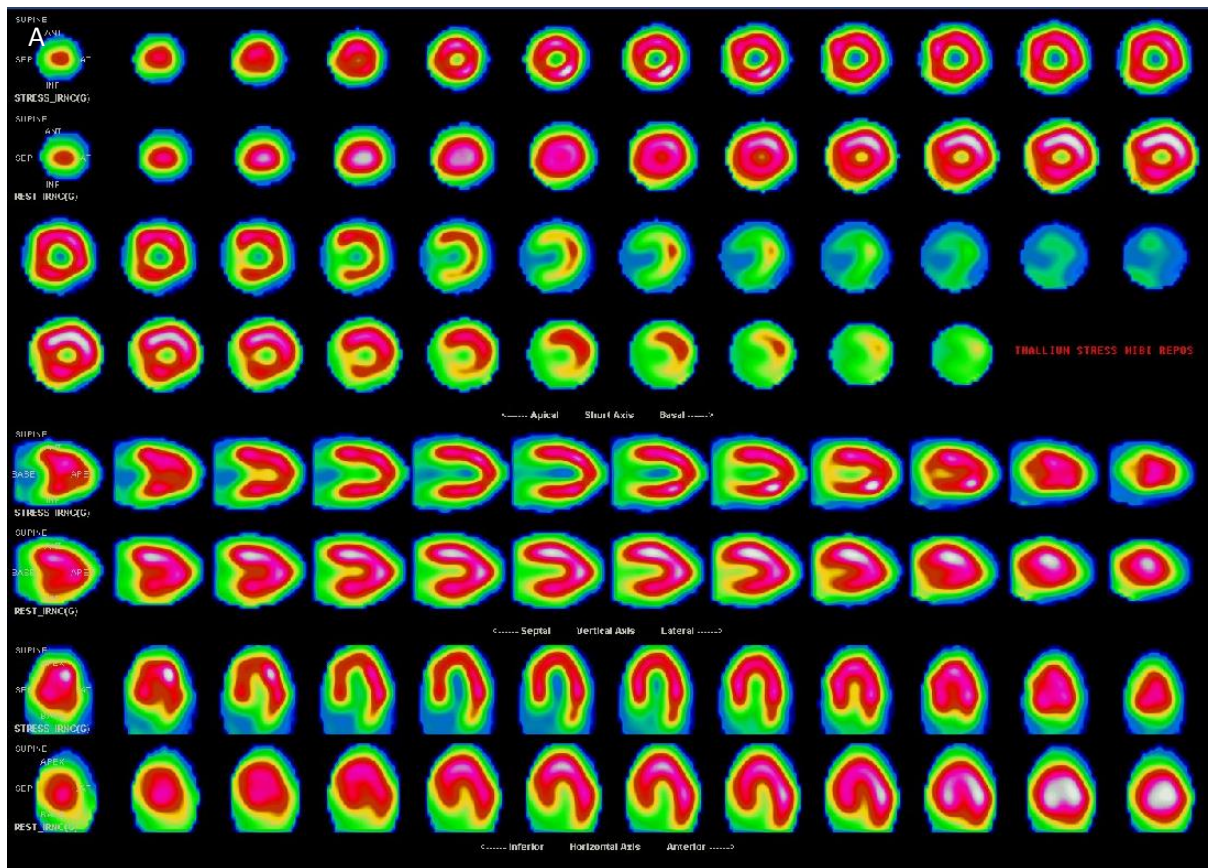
Example of SPECT MPI with SSS = 0 (A) and normal gated SPECT parameters (B).
